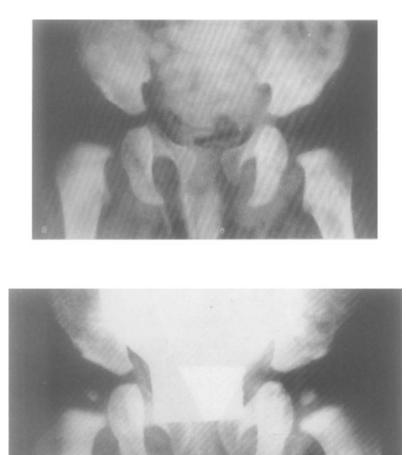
Girl with positive dislocation test in both hips at birth. When referred to SMOH at 10 days of age the test was negative. Treated by the Frejka pillow and plaster cast. X-rays show rightsided dysplasia, at 3 months (a), at 7 months (b), and at 10 months (c) and normal hips at 7 years (d).
